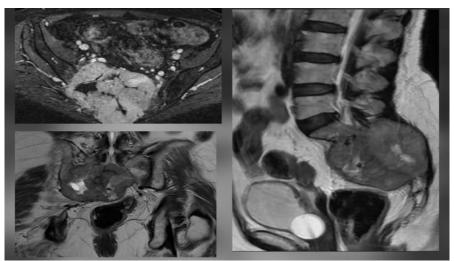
MRI of the lumbosacral spine showing a heterogeneous sacral mass (S1-S3) with canal occupation, bone destruction, pelvic extension, and gluteal muscle infiltration
